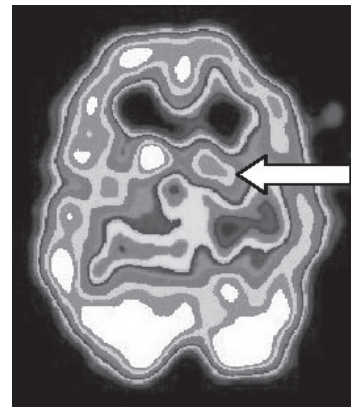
SPECT scan showing temporal hypoperfusion (white arrow) in a patient with postconcussion syndrome.
